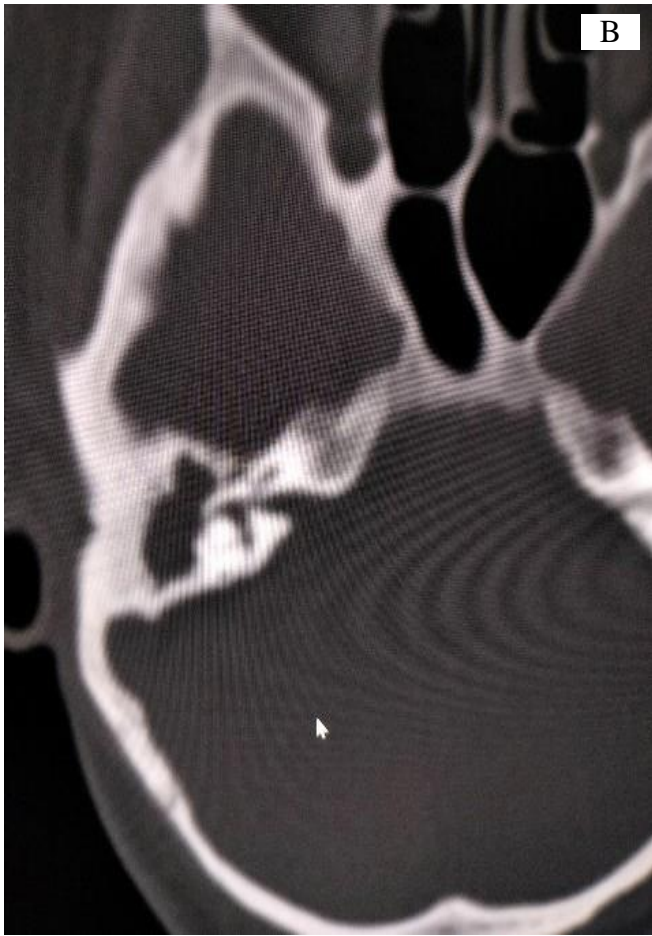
A: HRCT temporal bone axial section showing a defect in the right lateral semicircular canal. B: Intraoperative image showing a defect in lateral semicircular canal confirming labyrinthine fistula*
